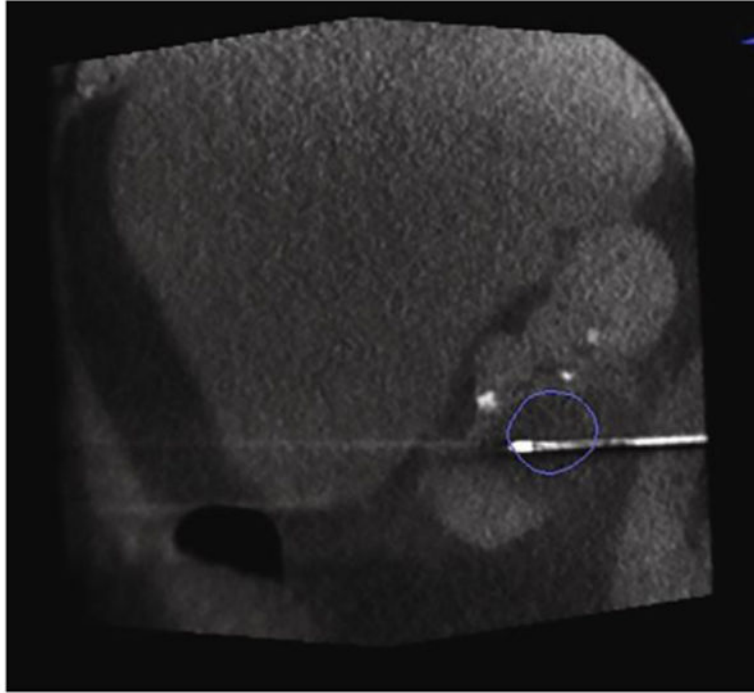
Contrast-enhanced CBCT image showing the segmented tumor (green circle). The cryoablation isotherm according to the manufacturer's specifications is also displayed. The planned needle path is displayed
